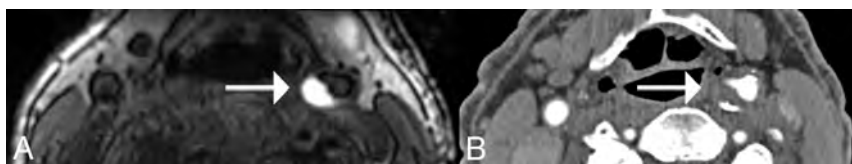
FIGURE Carotid IPH in a 77-year-old male participant. An axial MPRAGE (A) shows IPH(+) eccentric plaque at the left carotid bulb (arrow). The avid hyperintense signal on this heavily T1-weighted sequence is due to methemoglobin in the blood products. Axial CTA (B) shows the corresponding CTA appearance of this plaque. The predominantly noncalcified plaque (arrow) narrowed the vessel lumen by 62%.
